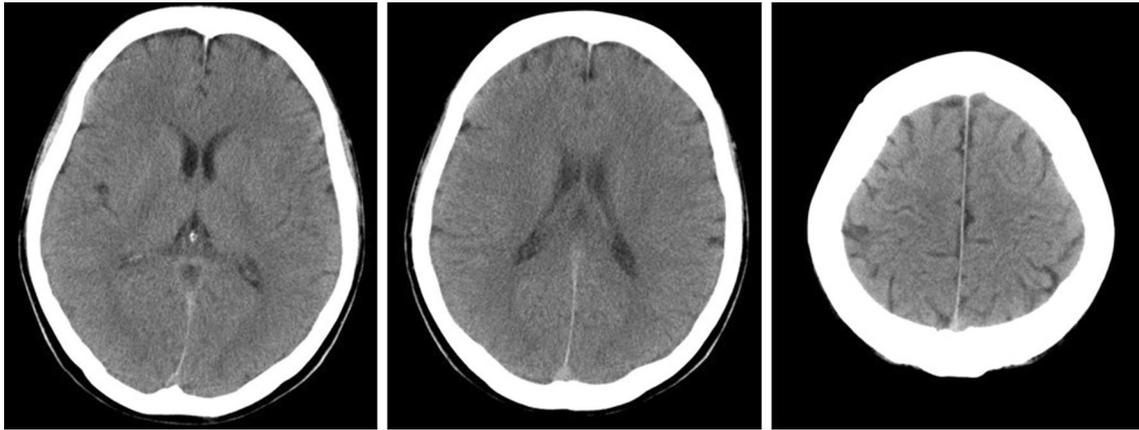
Although the patient was deeply comatose with a decerebrate posture on arrival at the emergency room, computed tomography of the brain revealed no sign of brain damage
